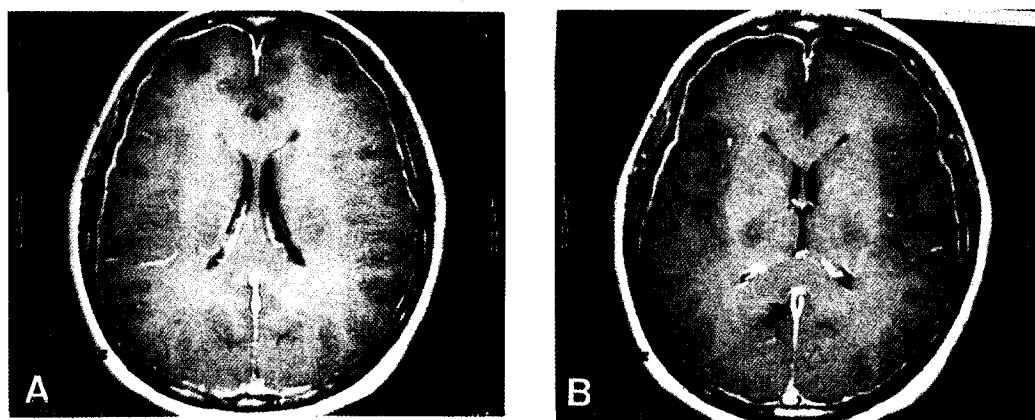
Axial view of gadolinium-enhanced T1-weighted MRI on admission. (A) The scan shows diffuse thickening and enhancement of the pachymeninges along both cerebral hemisphere and falx cerebri (arrows). (B) The scan shows thickening and enhancement of tentorium cerebelli (arrows)
